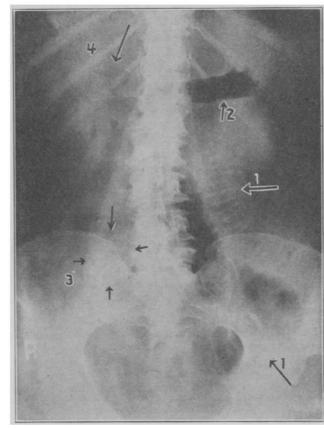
(case 2).—Roentgenogram of abdomen in supine position, 1, dilated loops of intestine filled with gas; 2, gas in the stomach; 3, shadow of impacted stone with facet on upper surface (this was not observed before operation); 4, faceted stone in gallbladder with gas above it, extending into biliary ducts. Presence of gas in the biliary tract, the remaining faceted stone in the gallbladder and evidences of intestinal obstruction permitted the exact diagnosis of gallstone obstruction.
